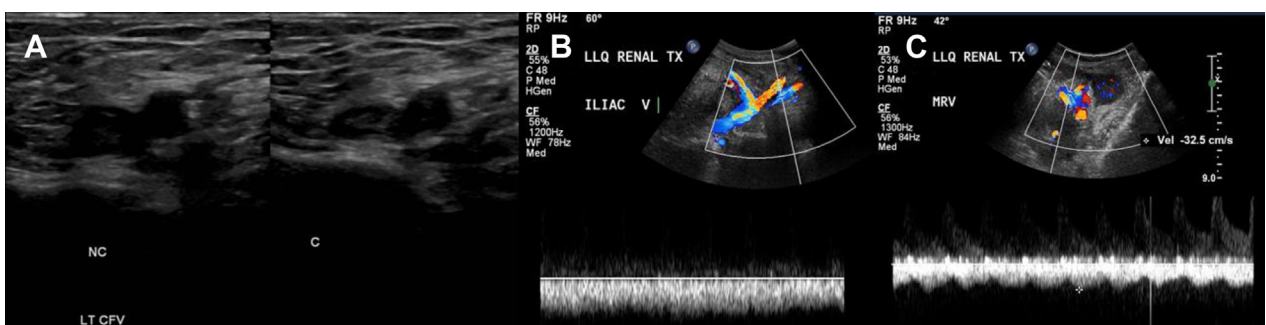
A, Ultrasound demonstrates left common femoral vein (*LT CFV*) thrombus. *C*, Compression; *NC*, no compression. B, Left external iliac vein (EIV) patent with adequate flow. C, Renal allograft venous anastomosis patent with adequate flow.
